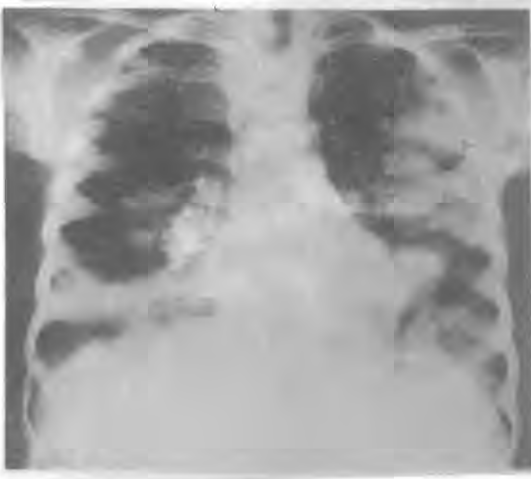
Routine frontal chest roentgenogram showing bilateral hydatid cysts in the right and left upper lung fields
